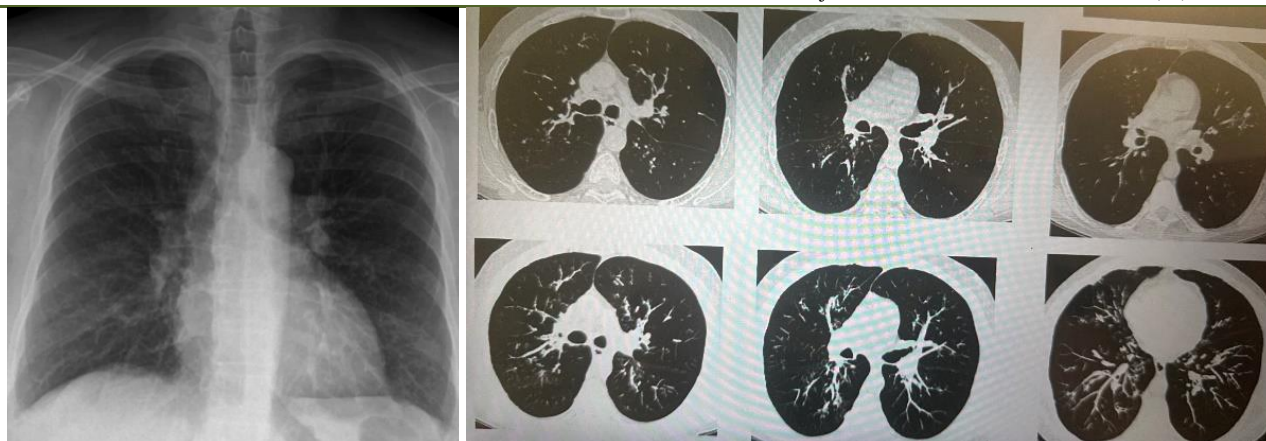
Chest X-ray and axial section of thoracic CT scan
